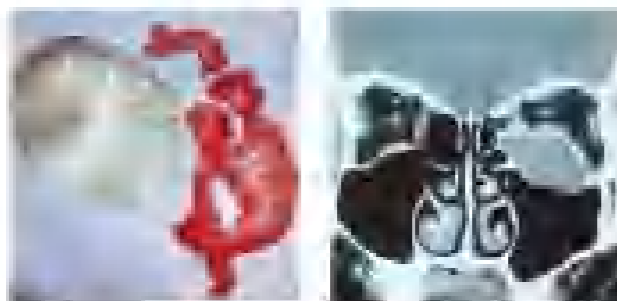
Left. The fibrovascular cyst and scleral patch removed from patient 2 during orbitotomy. Right. Coronal CT of patient 2 demonstrating a well-circumscribed mass arising from the inferomedial aspect of the left orbit.
